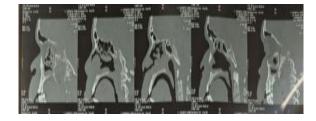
CT PNS sagittal view showing upper lip swelling.
